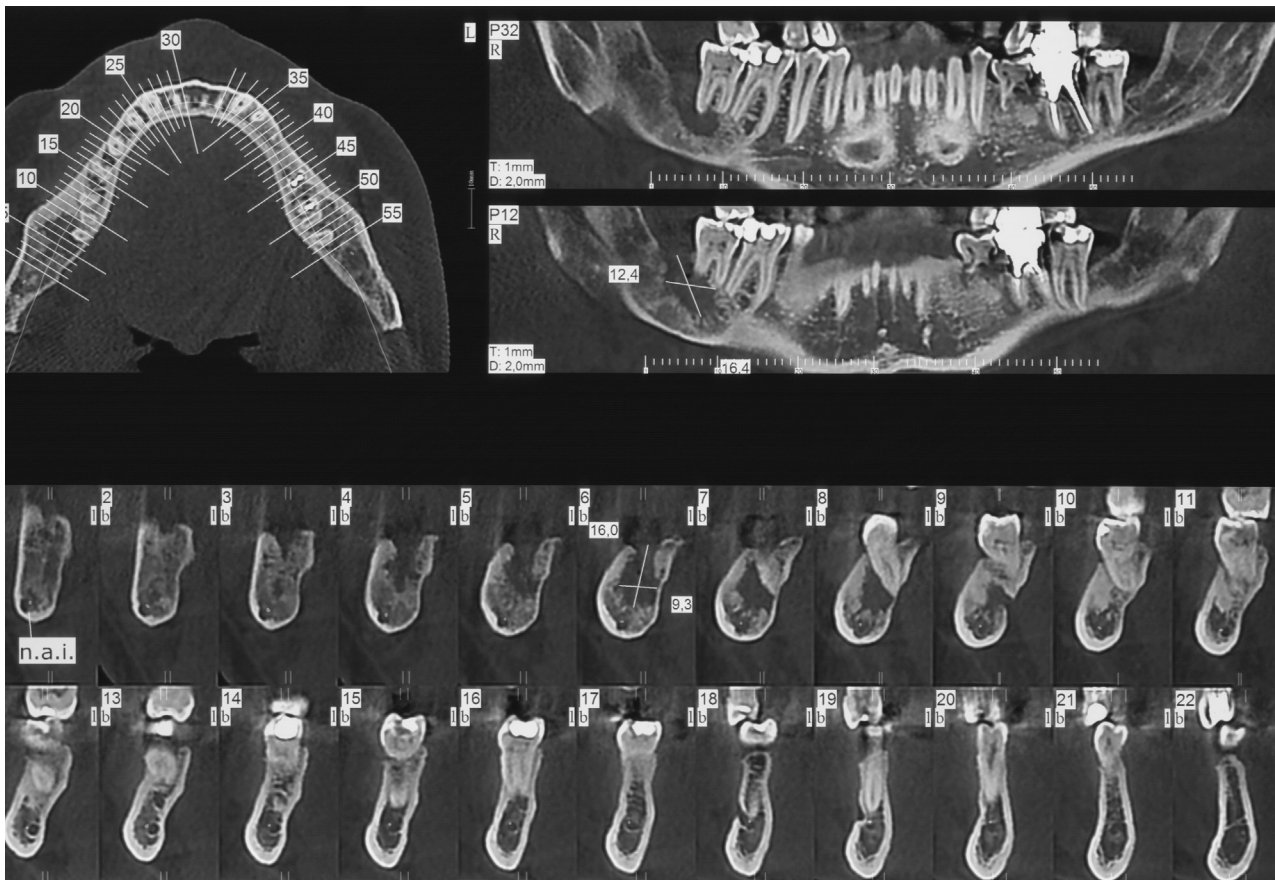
Cone-beam computed tomography cross-sectional slices after marsupialization and just before enucleation of the same lesion shown in Figure 1.
